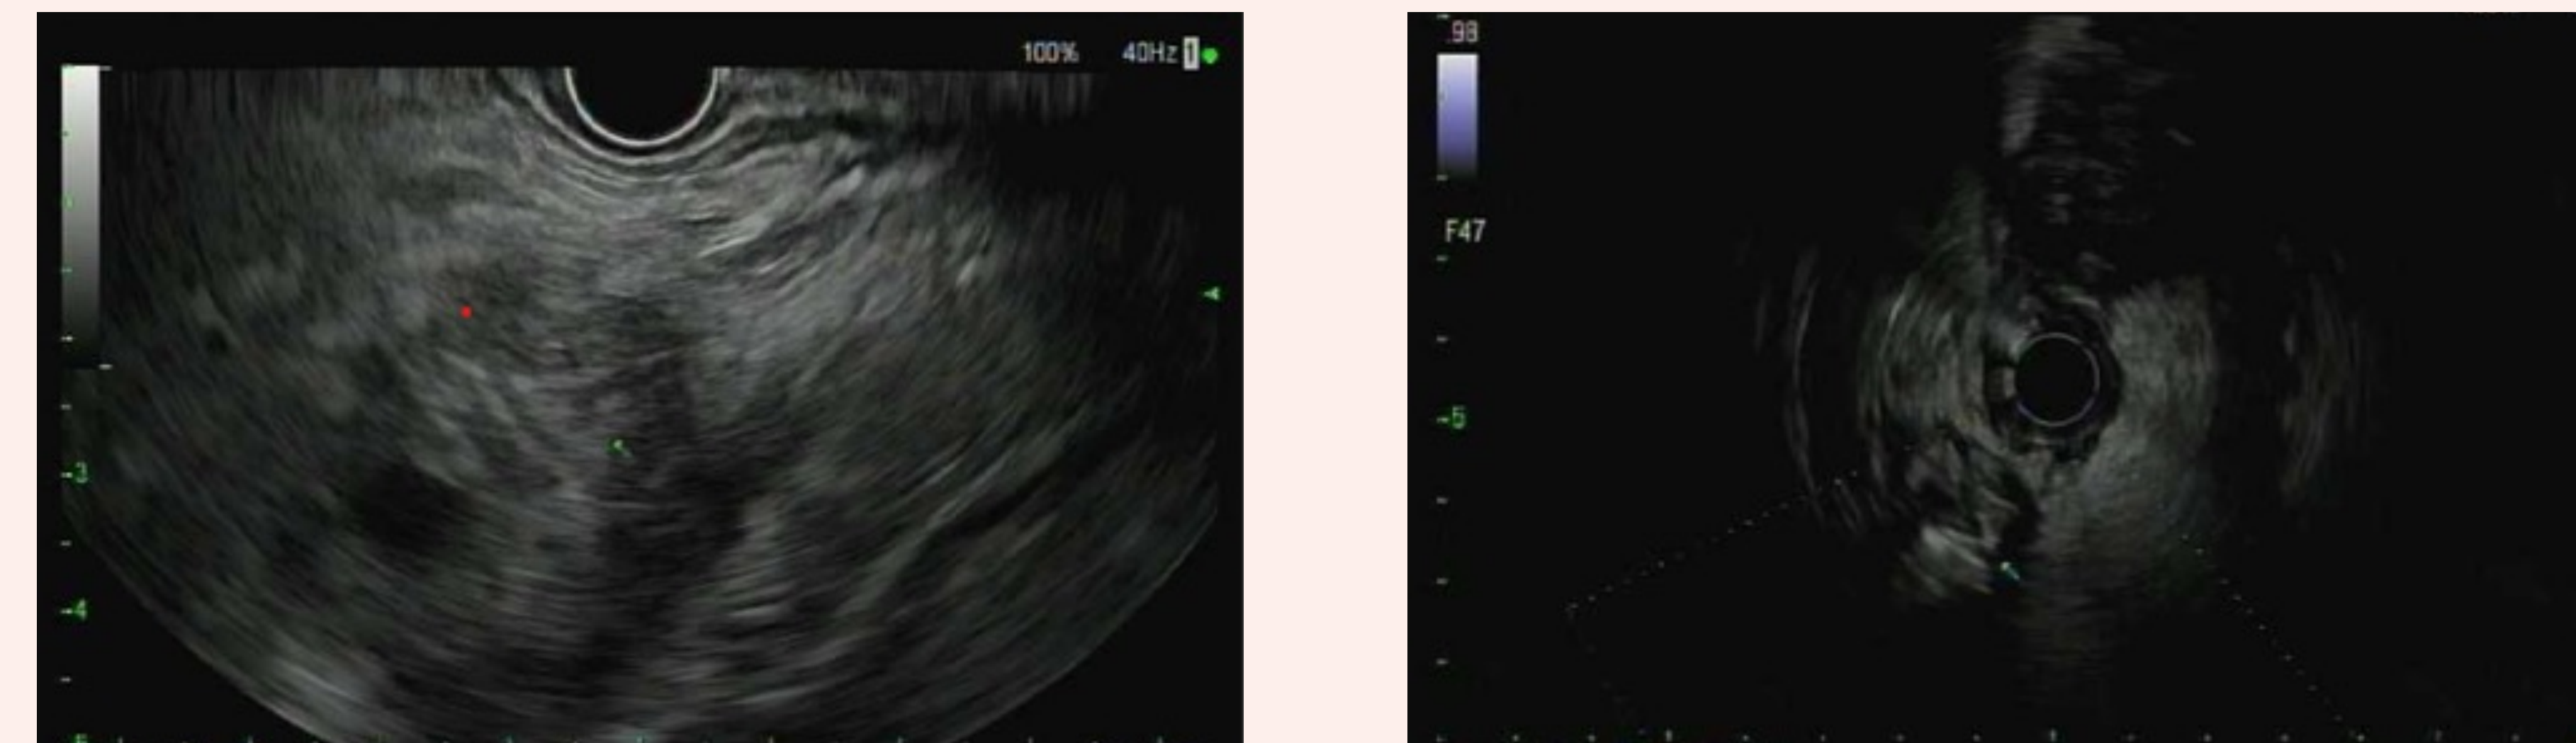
Endoscopic ultrasound of pancreatic head mass.
